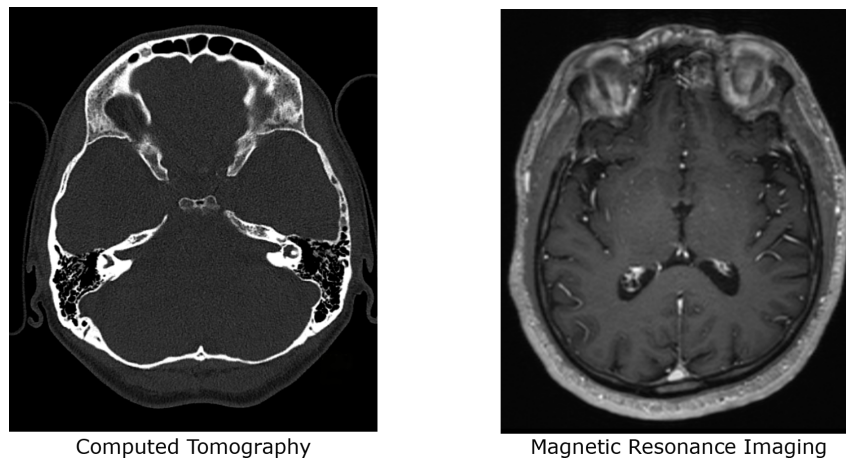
Two example images of CT and MRI. While the CT image provides more information about the bone structures of the patient, no details about the brain tissue are visible. On the right side, the MRI data presents much more details about the structure of the brain but less information about the dense structures of the body.
